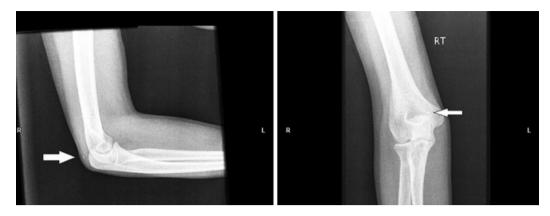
The bur is indicated by an arrow in lateral and anterior-posterior X-ray views.
